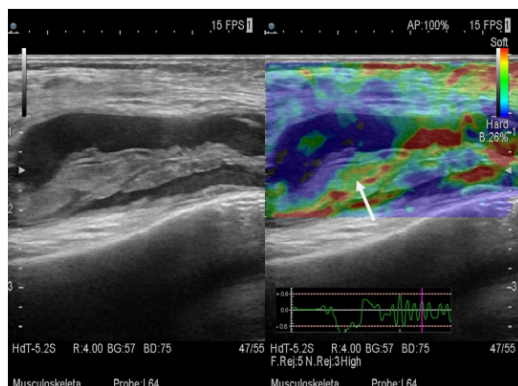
USG elastography of suprapatellar bursa showing thickened hypertrophied synovium (showed hypervascularity on doppler). On elastography soft colours are seen in synovium (white arrow) suggestive of synovitis later on confirmed as Tuberculosis.
